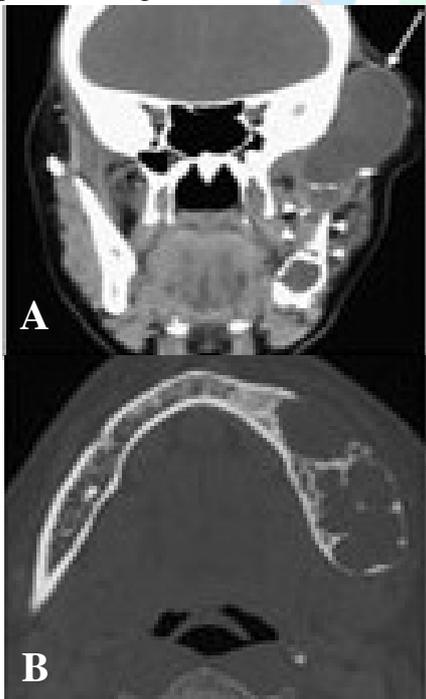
(a) and 5 (b): Coronal and axial CT showing multiple hypodense area involving left side Body and ramus of the mandible.
